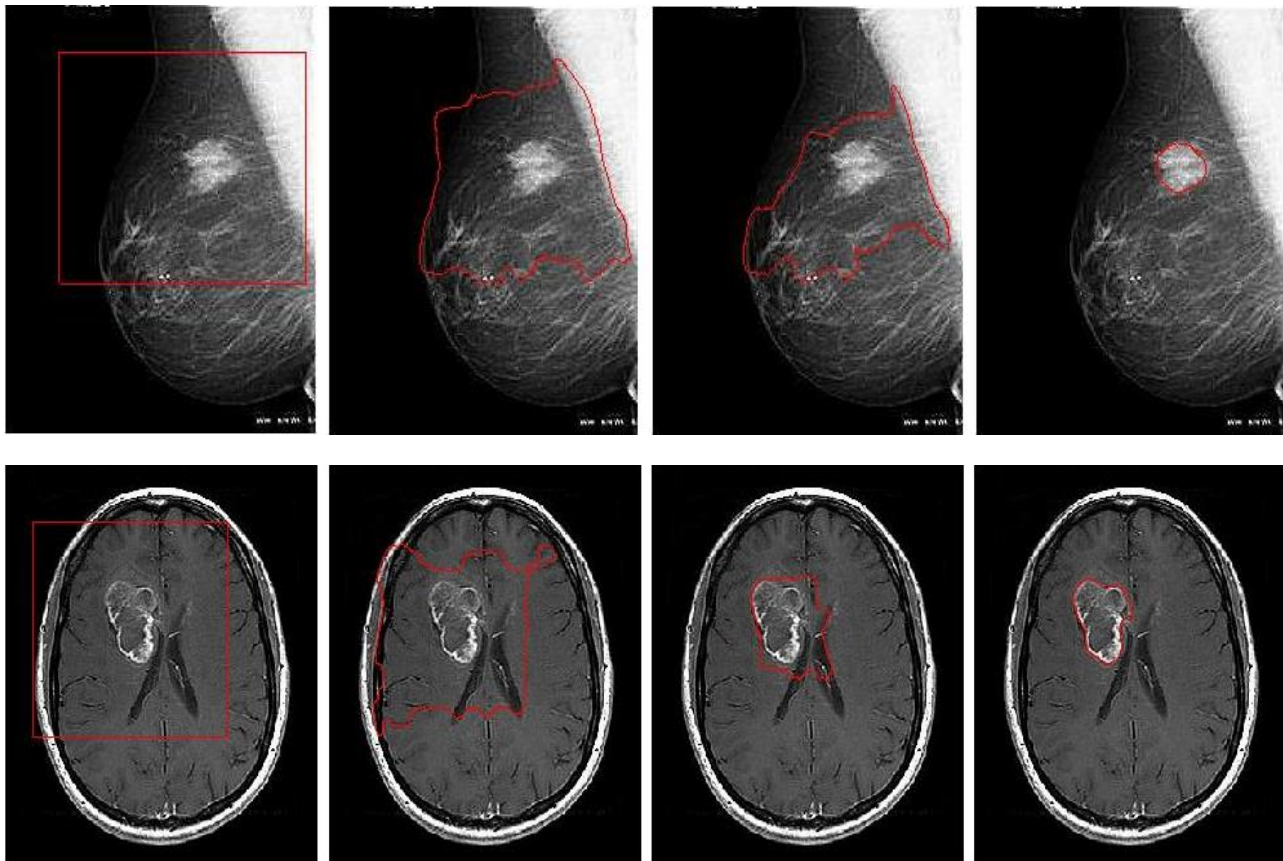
Four high-boost images belong to breast cancer mammography image, left to right, active contour initializing step on the original image, curve progress in 150 loop repeats, curve progress in 250 loop repeats, curve progress in 400 loop repeats. Four high-boost images belong to brain tumor MR image left to right, active contour initializing step on the original image, curve progress in 150 loop repeats, curve progress in 250 loop repeats, curve progress in 400 loop repeats.
